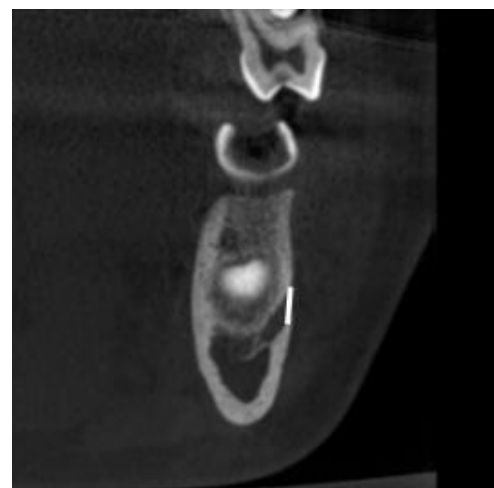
measurement of the vertical diameter of the mental foramen on the cross-sectional CBCT image
